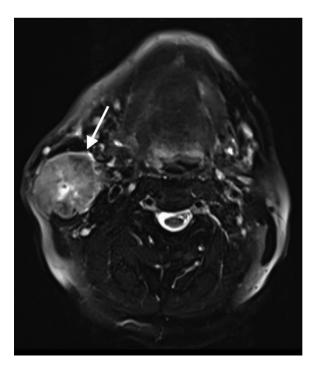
T2 axial image of the follow-up MRI study which demonstrates interval enlargement of the mass, progressive irregular contour and central necrosis.
